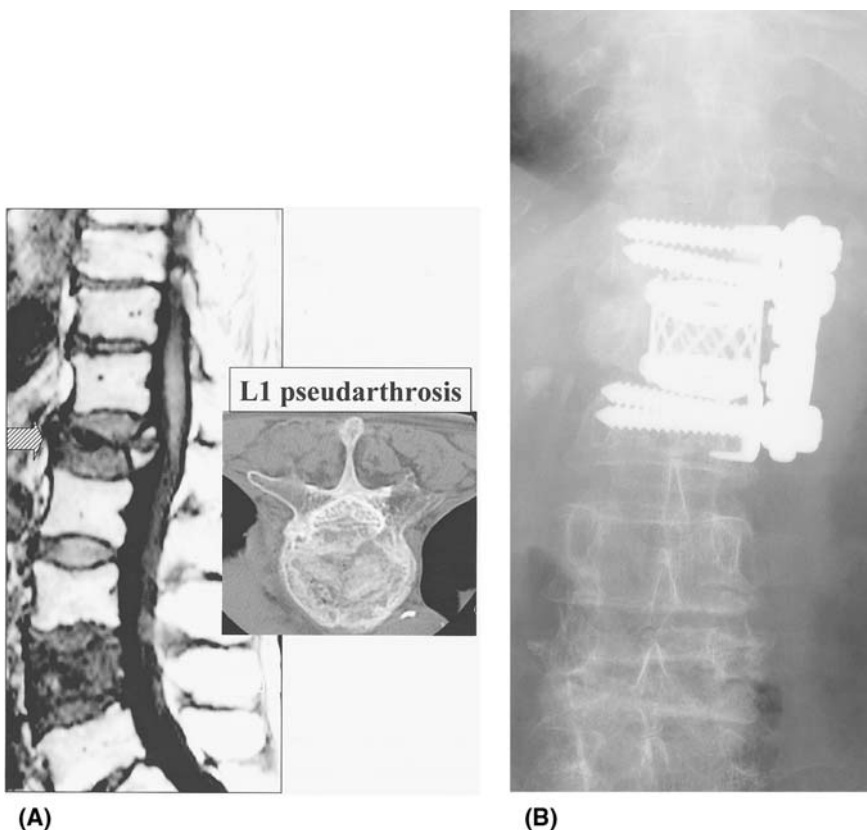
Case 2: a 78-year-old woman with osteoporotic L1 pseudarthrosis. (A) Preoperative MRI and CT myelogram; (B) radiograph one year after surgery.
